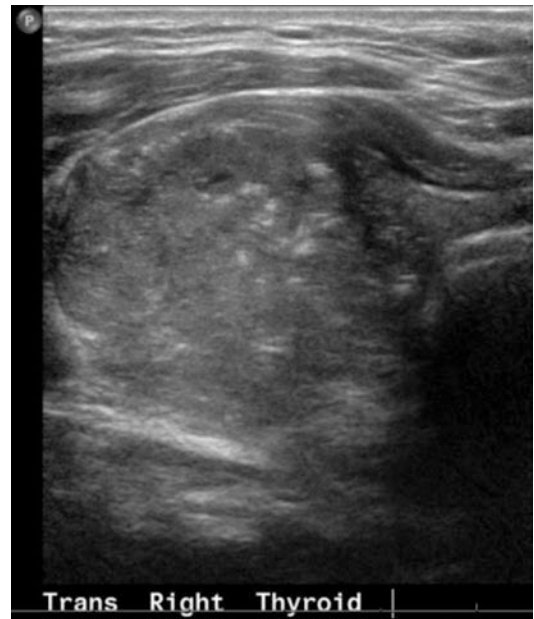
Ultrasound, right transverse
